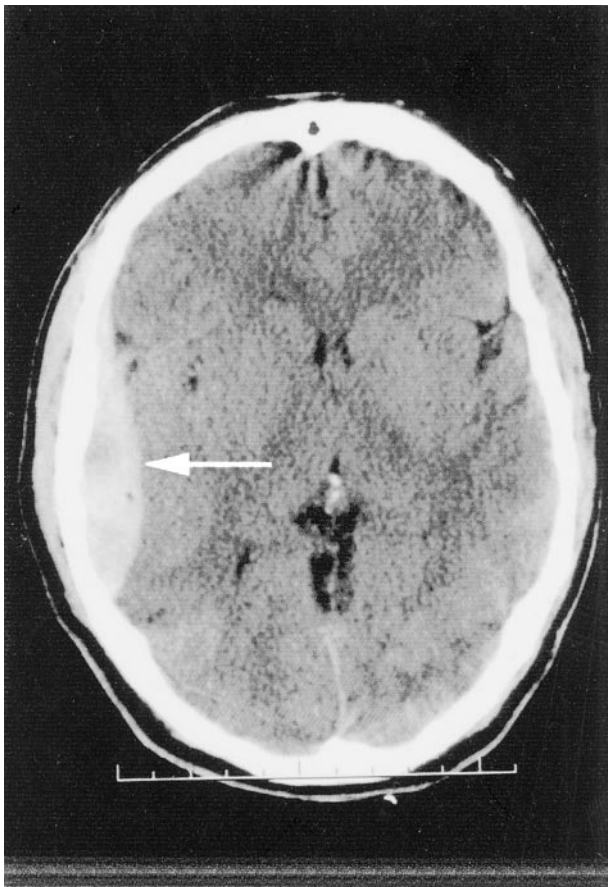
CT scan demonstrating a right temporal epidural hematoma (arrow).
